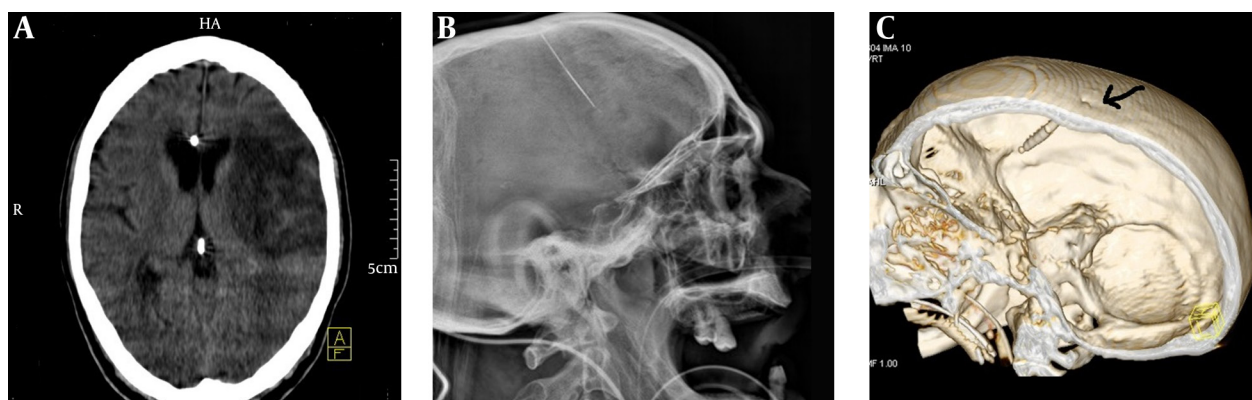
A, Brain CT scan on admission confirms infarction in left middle cerebral artery territory and presence of a metallic foreign body in mid-frontal region with slight right deviation. B, Three dimensional skull CT scan showing a sharp thin object in frontal region with length of 42 mm and a dimple in frontal bone proposing the entry site of sharp object (black arrow). C, Lateral view of skull X-ray confirms the presence of a sharp thin metallic object in frontal region.
